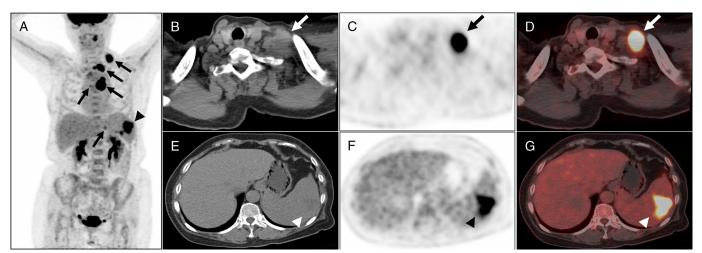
A 68-year-old woman presented with mental fatigue, poor appetite, and weight loss for 1 month. In addition, physical examination revealed enlarged left supraclavicular lymph node. She had no fever, cough, expectoration, or nighttime sweating. Her leukocyte count was 18.1×10^{9} /L (reference, $3.5-9.5 \times 10^{9}$ /L), neutrophil count was 14.5×10^{9} /L (reference, $1.8-6.3 \times 10^{9}$ /L), platelet count was 672×10^{9} /L (reference, $125-350 \times 10^{9}$ /L), and serum creatinine level was within the reference range. ¹⁸F-FDG PET/CT was performed to aid in diagnosis. As showed in MIP of ¹⁸F-FDG PET, elevated ¹⁸F-FDG uptake in left inferior cervical, left supraclavicular, mediastinal, and splenic hilum lymph nodes (A, arrows), and spleen (A, arrowhead) were revealed. Representative lymph node (B–D, arrows; SUV_{max}, 16.9) and spleen lesions (E–G, arrowhead; SUV_{max}, 12.0) in the axial CT, PET, and fusion PET/CT images were exhibited. However, it is not easy to make a diagnosis with ¹⁸F-FDG PET/CT only.
